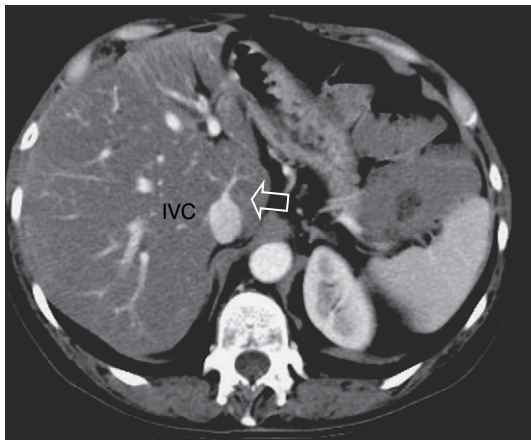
CT scan at the level of the mid-liver in a patient with marked fatty infiltration. Note several small hepatic veins (arrow) draining directly into the inferior vena cava (IVC). Because of this unique drainage of the central liver, this segment behaves differently in patients with main hepatic vein thrombosis or cirrhosis. The ultrasound appearance may be altered. Hypertrophy may be perceived.
